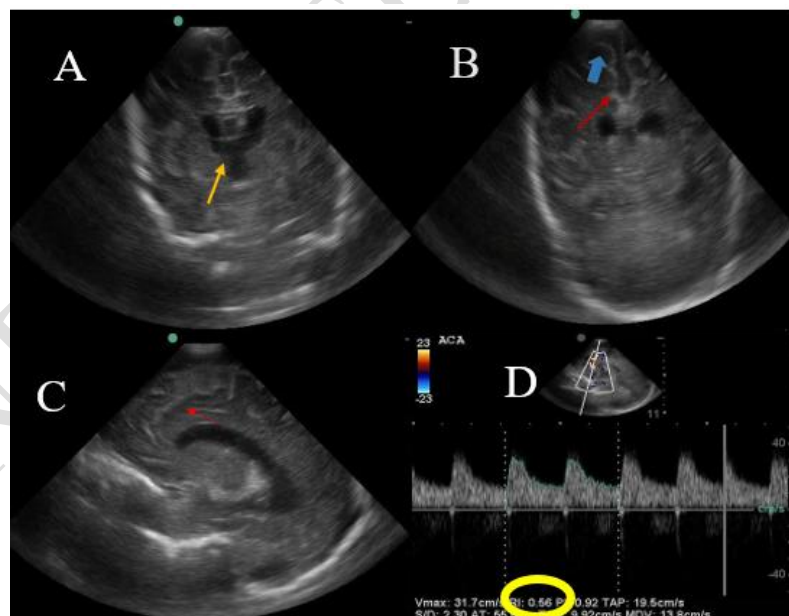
(A-D images): coronal scan through (A) thalami, and (B) foramen of Monro show enlarged subarachnoidal space (blue arrow head), widening interhemispheric fissure (red arrow), and prominent ventricles (yellow arrow). (C): sagittal scan through the caudothalamic groove shows reduced complexity of gyral fold (red arrow). (D): color Doppler image shows low RI of ACA (yellow circle)
